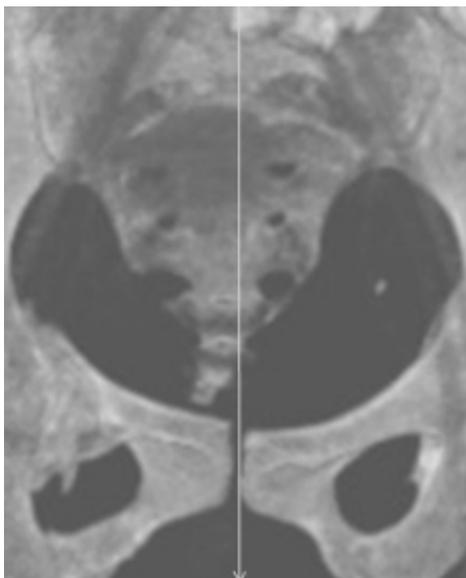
CT image of coccygeal lateral deviation (White arrow represents the midline)
